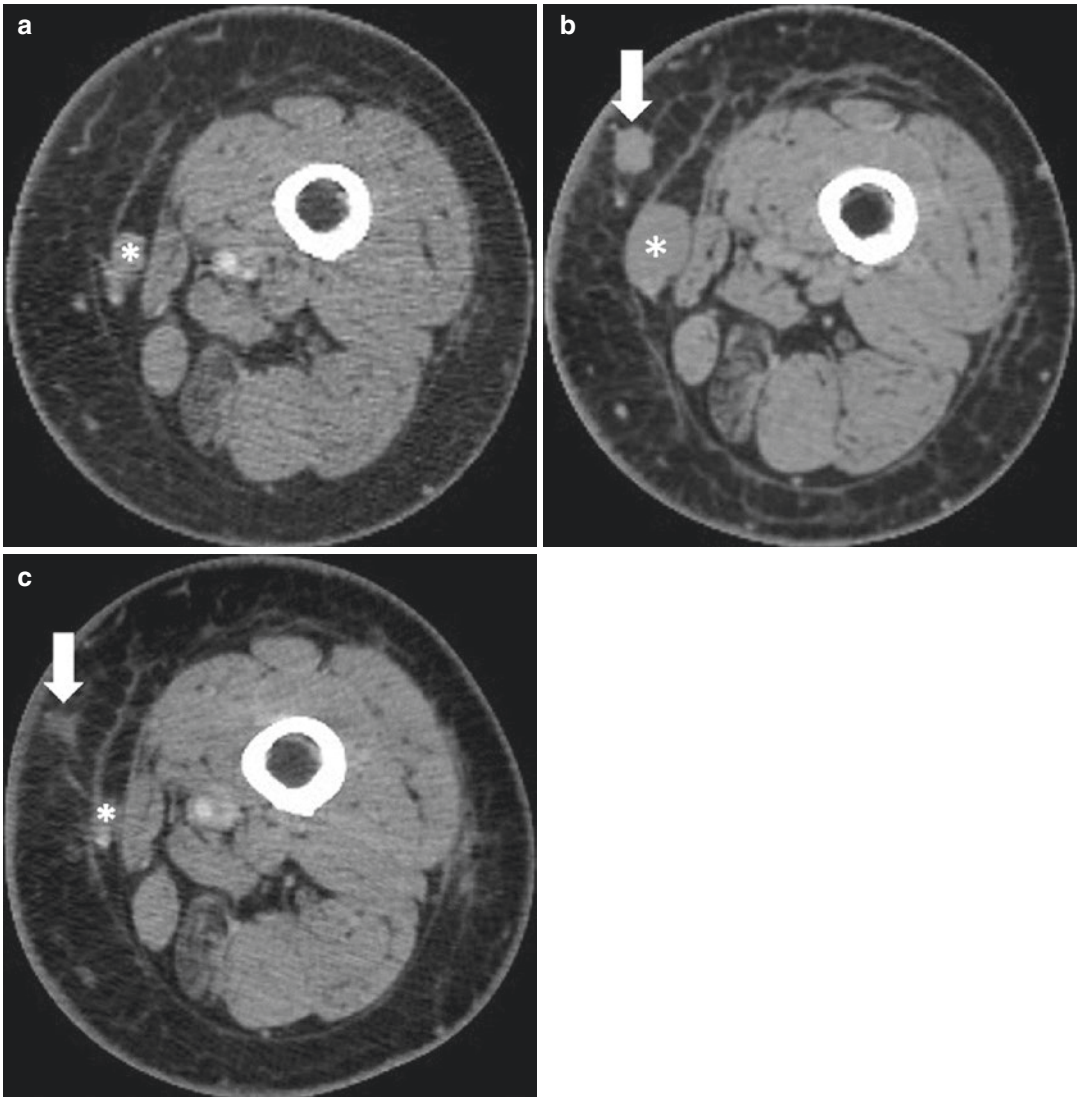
Pseudoprogression with appearance of a new lesion followed by subsequent immune-related response in a 66-year-old woman with metastatic melanoma treated with nivolumab and ipilimumab. (Reprinted with permission from *Radiology*. 2019 Jan;290(1):9–22). Compared with (a) a baseline axial CT image obtained prior to the initiation of therapy, (b) a follow-up axial CT image obtained after 3 months of therapy shows a new subcutaneous lesion (arrow), indicating progressive disease
